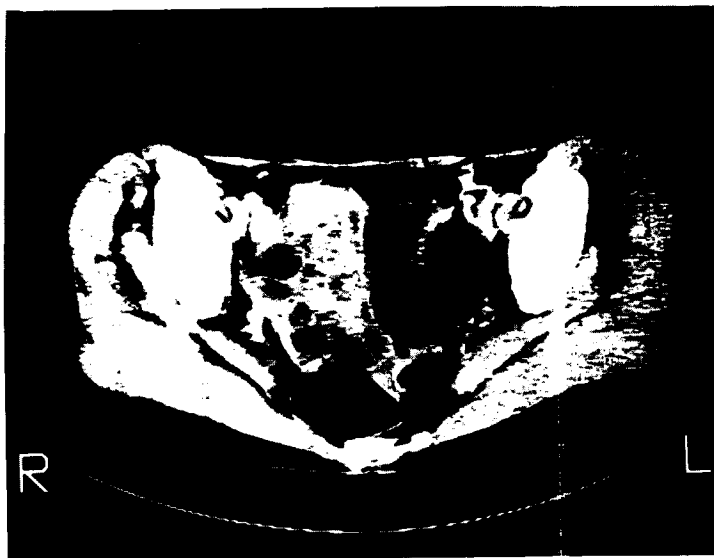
CT scan of pelvis. Three well defined cystic structures are seen on the left side.
